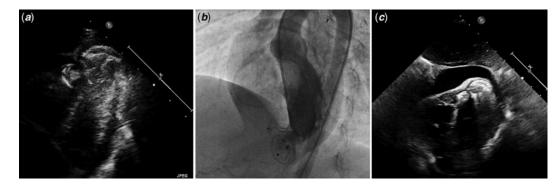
(a) Echocardiography showing Amplatzer septal occluder device occluding left ventricular pseudoaneurysm. (b) Left ventriculography confirmed total occlusion of the pseudoaneurysm. (c) Echocardiography showing post-procedural pericardial effusion.
